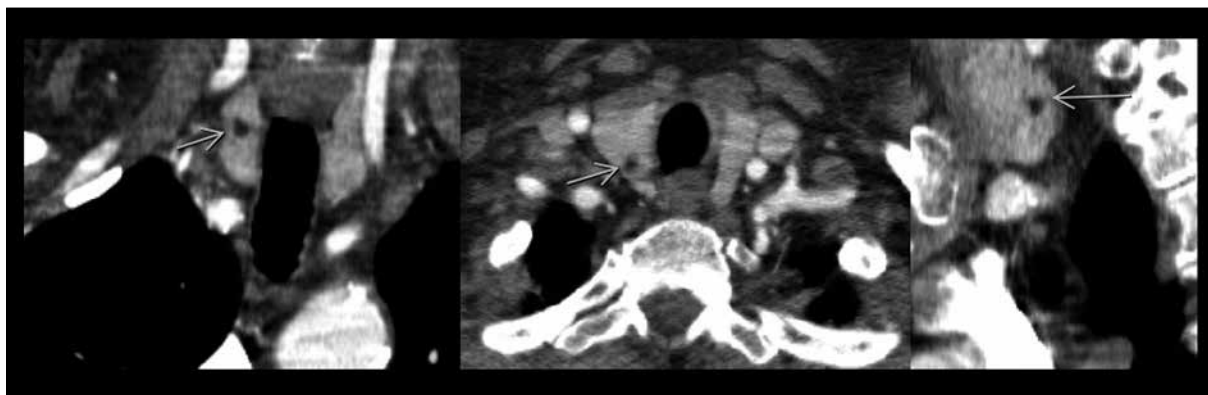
Thyrolipoma on computed tomography of the chest in a 70-year-old woman undergoing imaging because of a suspected pulmonary embolism. There is a well-circumscribed fatty mass in the right lobe of the thyroid (arrows).
